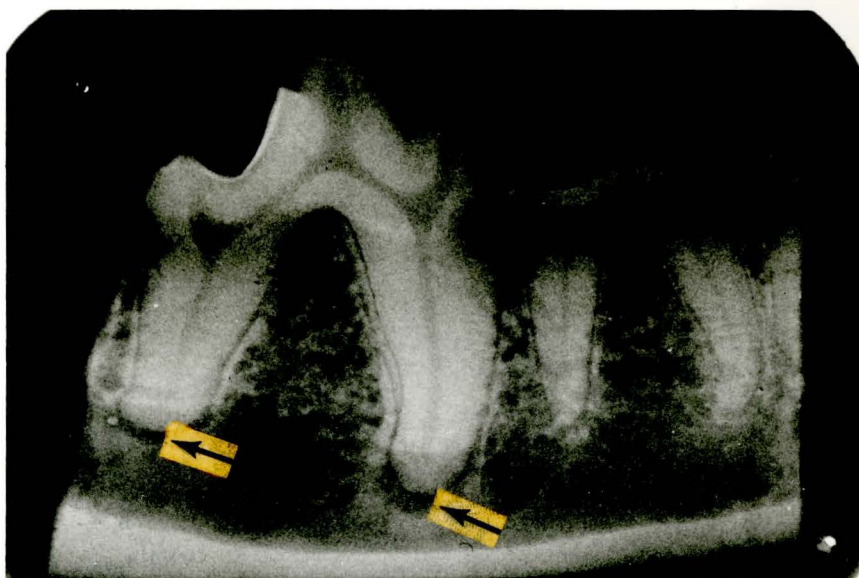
Radiograph showing the wide PDM spaces which are normal at the root apices of the Beagle 1st molar (arrows).
